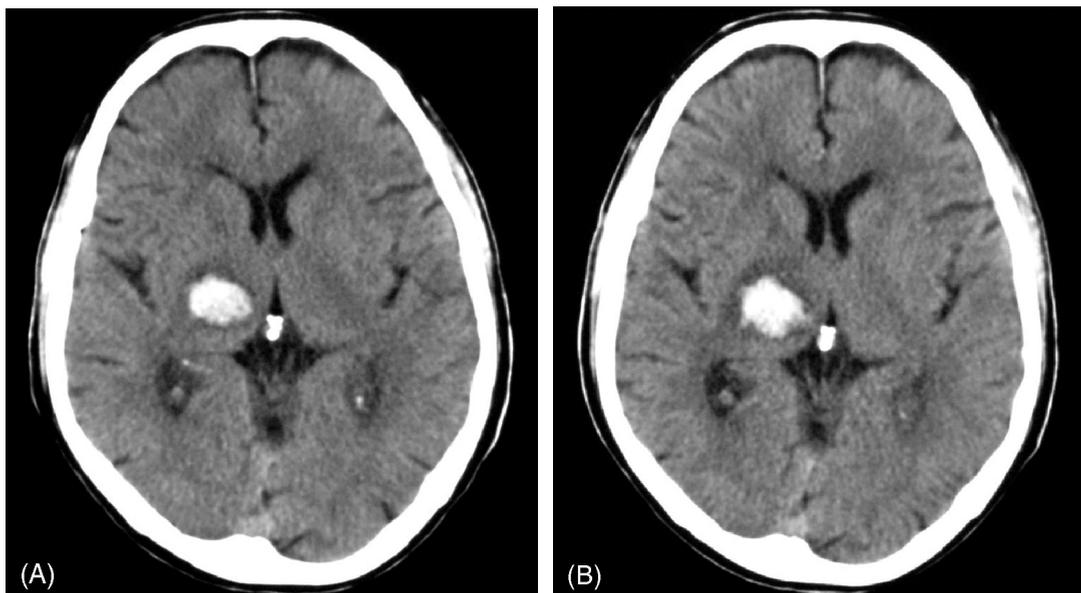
(A) Finding of a 63-year-old male with thalamic hemorrhage on the day of hemorrhage. (B) CT finding on the next day.
